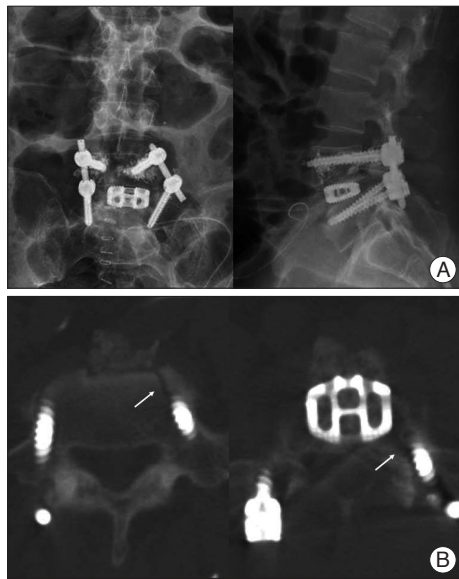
Plain radiographs (A) and CT images (B) after the first revision surgery. A : The pedicle screws were unstable and replaced with thicker and longer ones, but two L4 screws remained loose. Therefore, cement was used to augment the L4 screws. B : CT images showing the pedicle and lateral body wall fracture in the L5 vertebra (white arrows).
